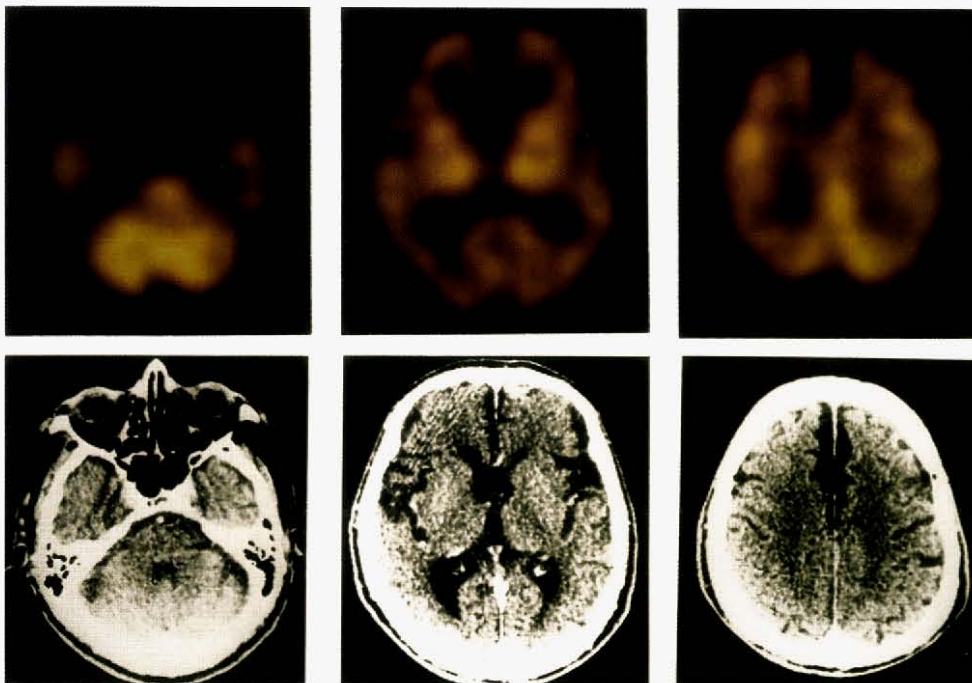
61-year-old male with severe cerebral atrophy on CT. Transaxial images of ^{123}I -IMP SPECT are symmetrical. Regional CBF has decreased to 46 ml/100 g/min in the frontal cortex, and to 41 ml/100 g/min in the parietal cortex. This case was not combined with Alzheimer's disease.
